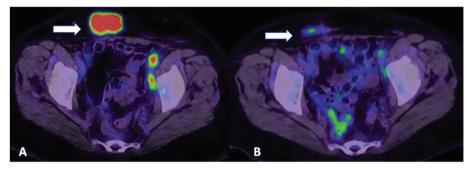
Treatment response evaluation. ¹⁸F-FDG PET/CT images obtained from a 68-yr-old patient with recurrent ovarian carcinoma for assessment of treatment response. Image A demonstrates an intensely FDG-avid metastatic abdominal mass on pre-treatment FDG PET/CT, with significant post-treatment improvement noted on Image B.
